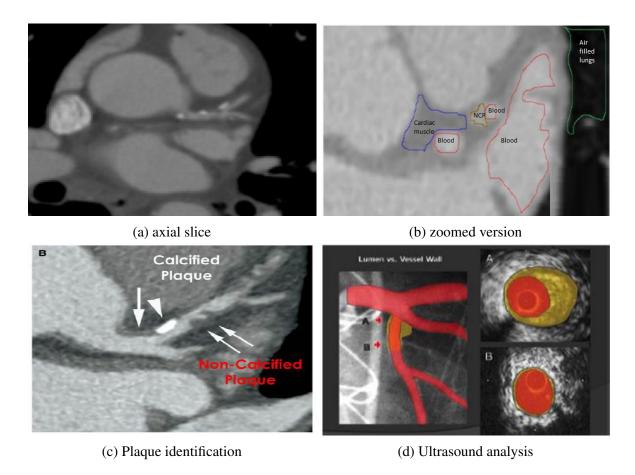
Non-invasive imaging for coronary analysis. (a) the intensity response (axial plane) showing different components inside the field of view of a cardiac CTA image, (b) zoomed version from an axial plane with annotations for different intensity responses. (c) shows the plaque visualization in CTA imagery, whereas (d) shows an ultrasound based appearance for the coronary vessel. It can be observed from (c) that calcium based plaque appears brighter in CTA due to high intensity, whereas lipid based non-calcified plaque appears relatively dull. Moreover, the IVUS based representation for the lumen and plaque can be visualized in (d).
